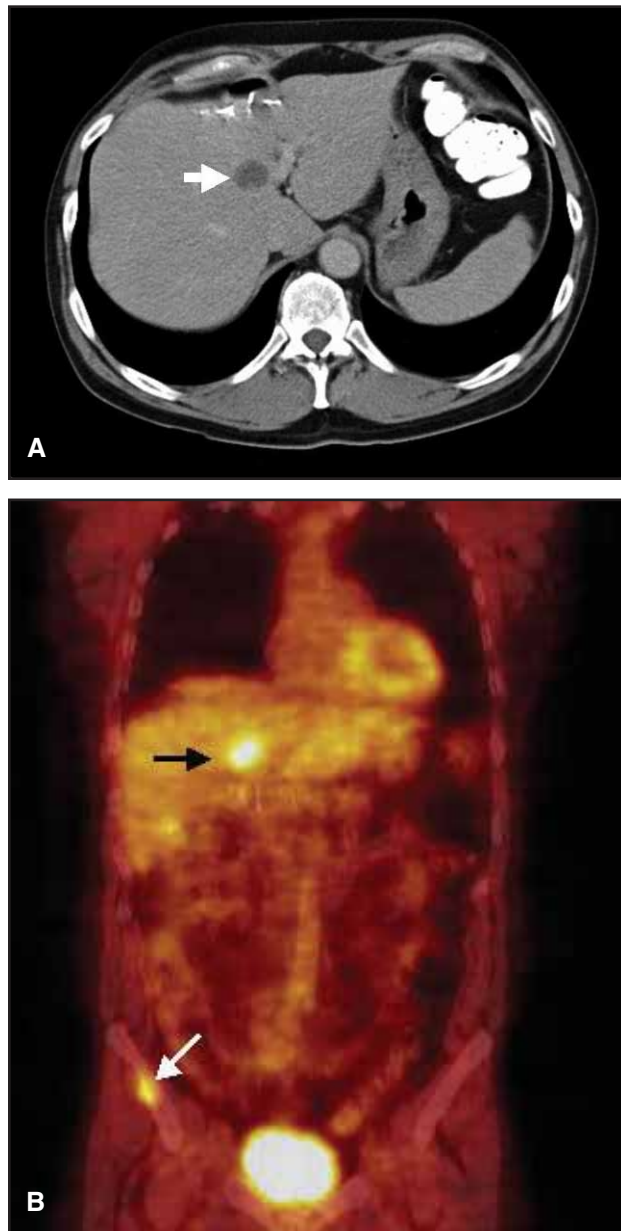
(A) Axial CT scan image demonstrates biopsy-proven local recurrence of liver metastasis following liver resection in the medial segment of the left lobe of the liver as a rounded low attenuation lesion (arrow) with no additional spread of disease. (B) Coronal image from a PET scan demonstrates the recurrent liver metastasis (black arrow) corresponding to the lesion seen on the CT scan as well as an unsuspected bone metastasis to the right iliac bone (white arrow)
